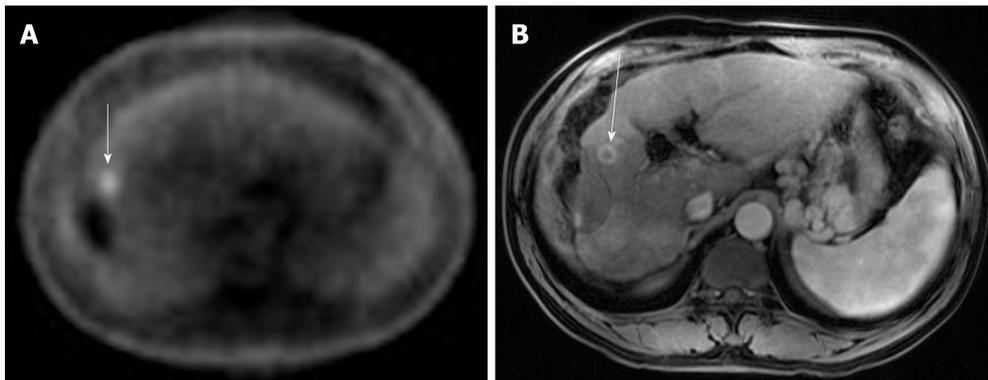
Case 3. A: Positron emission tomography scan: the white arrow indicates a small focus of fludeoxyglucose uptake adjacent to the treatment zone showing absent metabolic activity; B: Multi-phase magnetic resonance imaging: the white arrow points to focal bleed at the periphery of the treatment zone post microwave ablation without evidence of any viable tumor during the arterial phase.
